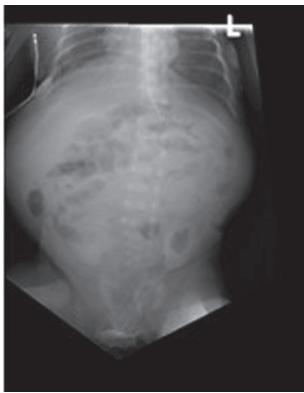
Case 1. Abdominal x-ray two days after application of support.
